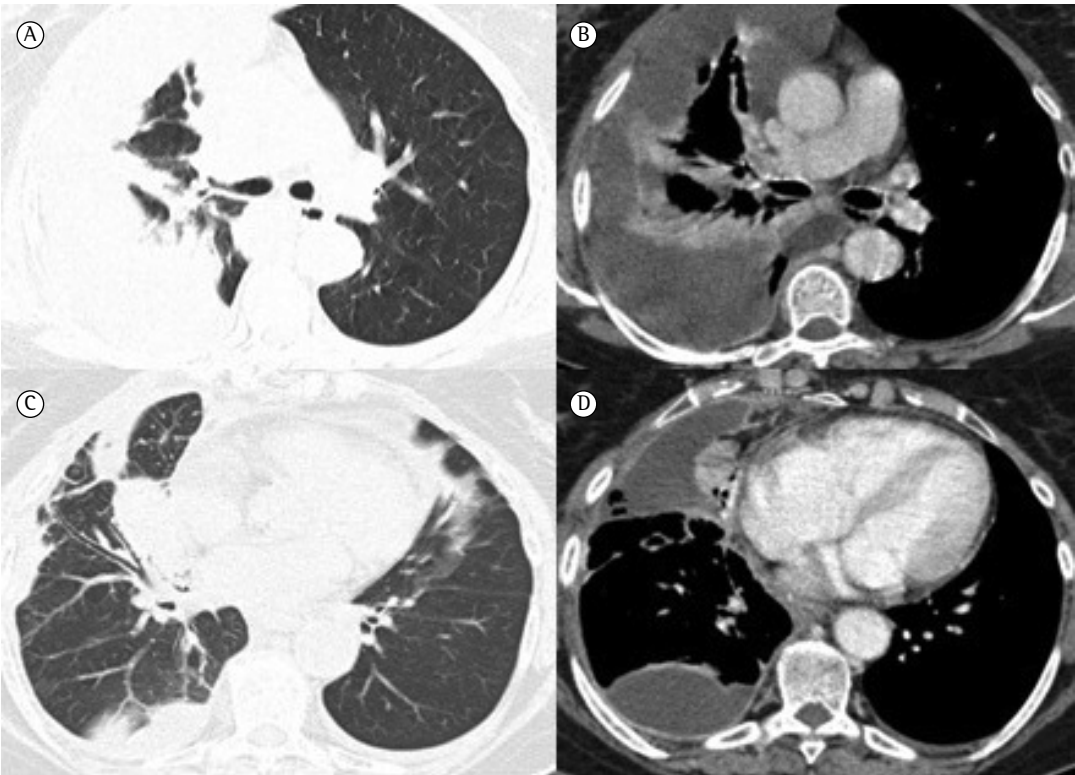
Chest CT scans. In A and B, initial CT scan showing right pleural effusion with ipsilateral parenchymal atelectasis. In C and D, post-drainage CT scan showing residual sites of pleural effusion with a nodular formation in the medial segment of the middle lobe, with contrast enhancement.
